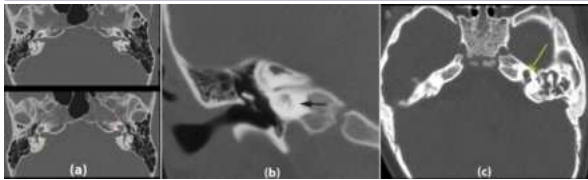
The temporal bone HRCT demonstrating (a) patent cochlea, (b) obstructed cochlea, and (C) Cochlear anomaly (common cavity).
